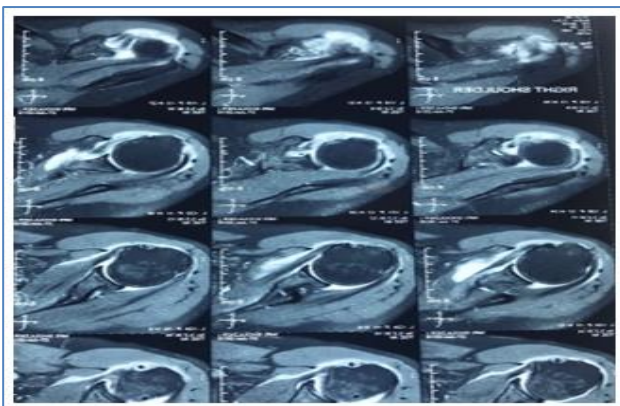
Axial sections of MRI showing supraspinatus tear.
